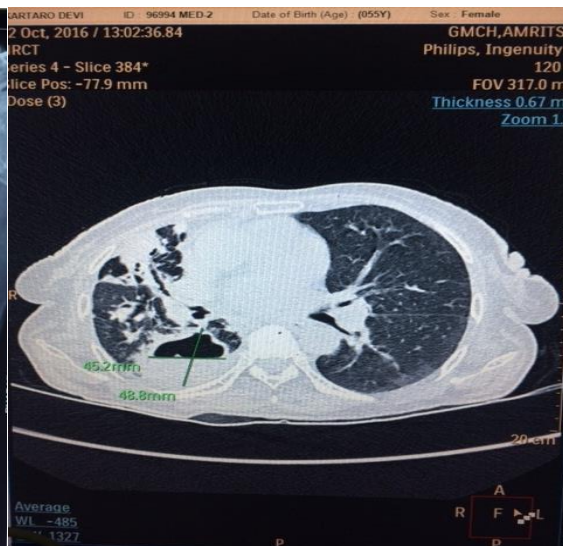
A contrast enhanced computed tomography (CECT) of chest
